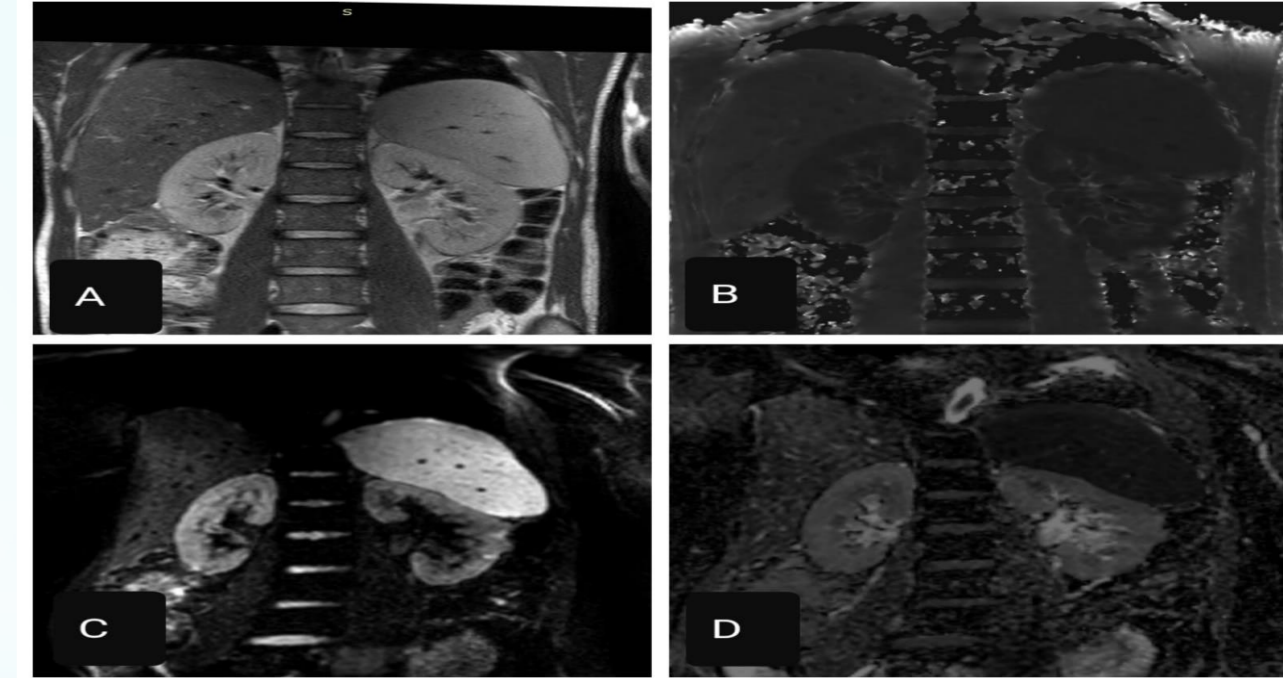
(A) Coronal T2WI of both kidneys showed no abnormal signal. (B) Coronal R2* map showed mean C-R2*=(18.06/s) and mean M-R2*=(33.85/s) and calculated MCR =1.9. (C) Coronal DWI (high b value) showed no evidence abnormal high signal within the parenchyma (D) Coronal ADC map showed no visual significant signal abnormality within the parenchyma with mean C- ADC value=2.66 x10-3mm2/s and mean M-ADC value=2.09 x10-3mm2/s.
